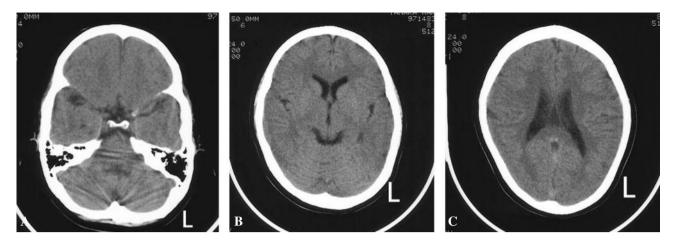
A, B, C. CT with axial sequences at age 10 showing equivocal atrophy of cerebral white matter without definite abnormality in the brainstem or cerebellum.
